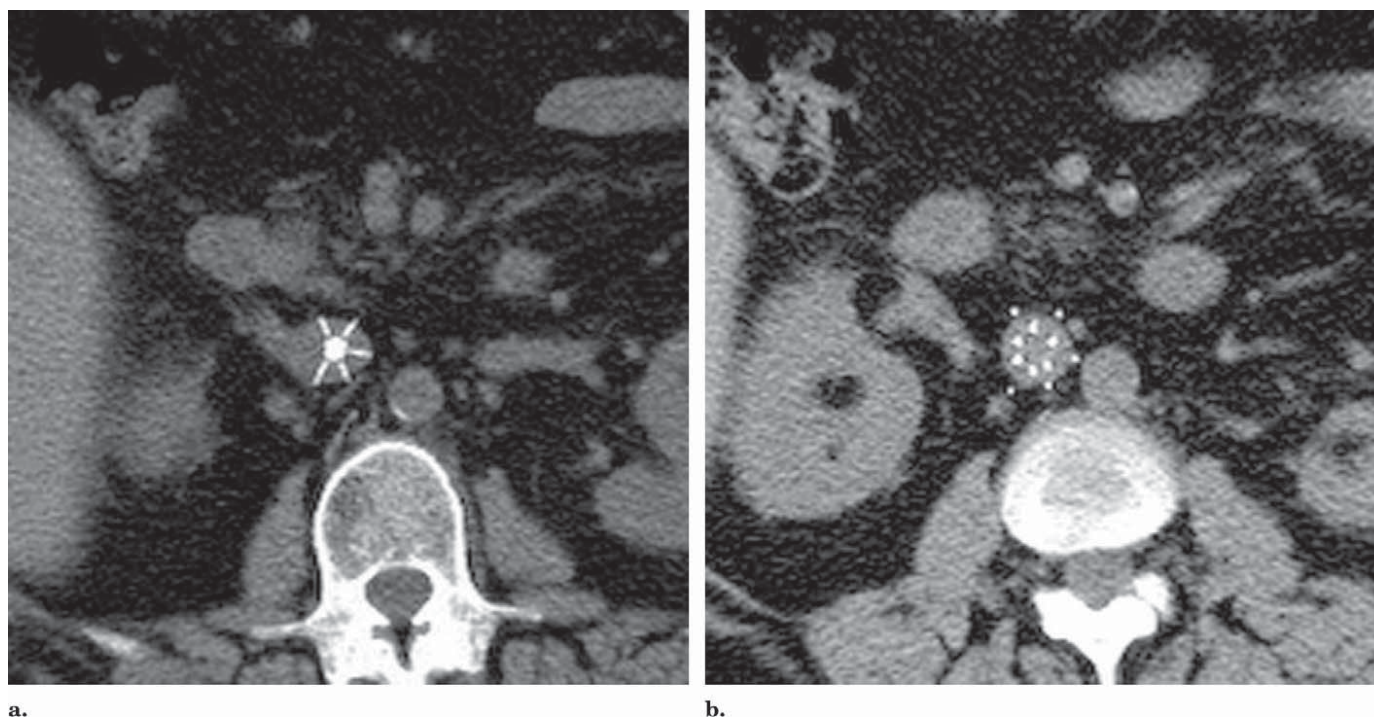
Abdominal CT findings of fracture. (a) At the top of the filter, the cap is in the center of the IVC. Only five arms are present (compare with Fig 1a). The arm at nine o'clock is absent. (b) The most caudal image demonstrates the tips of the remaining arms: three arms have perforated the IVC, extending beyond the IVC wall. Arms at 3 and 6 o'clock were not counted as perforations because of a lack of a clear acute angle of tissue between the arm and the IVC wall.
